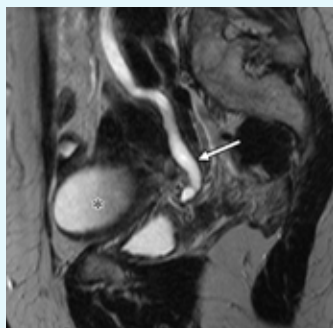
Sagittal T2-w MRI scan in a 50-year-old woman showing a right hydronephrosis (arrow) due to infiltration by cervical cancer; this is consistent with a stage IIIB cancer. Haematometra (*) is present due to cervical stenosis.
